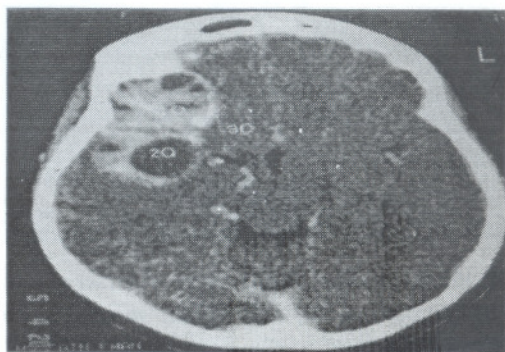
Contrast enhanced axial CT scan of brain shows-heterogeneous enhancing mass lesion with cystic component, few having fluid fluid levels.
